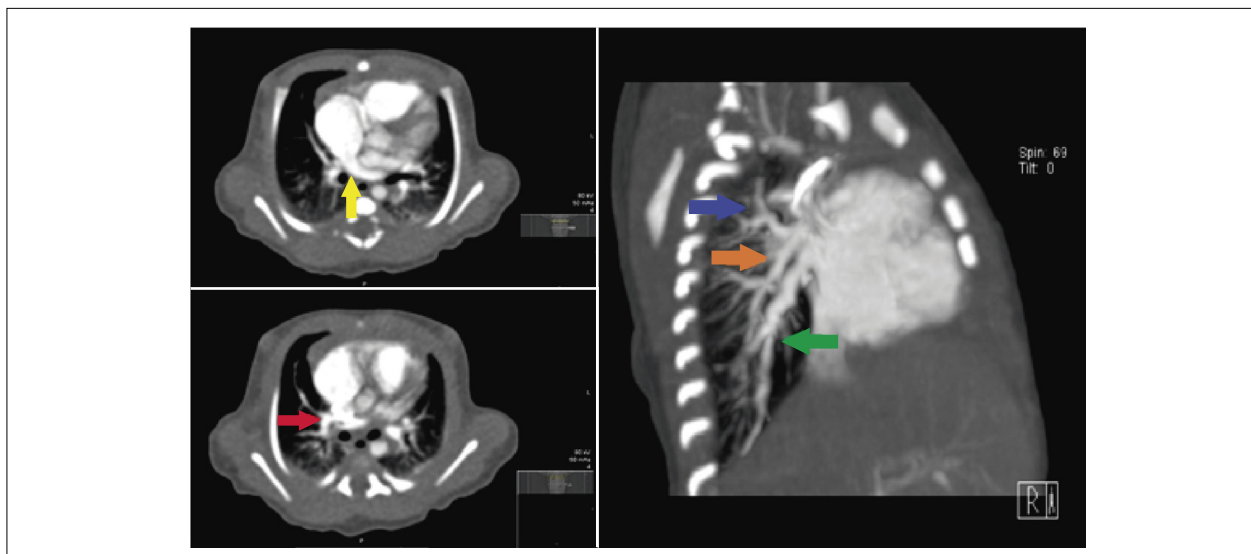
Axial view of the chest Computed Tomography Angiogram (left sided images) showing a common trunk coming from the left pulmonary veins and draining into the right atrium (yellow arrow) and the right inferior pulmonary vein merging into the aforementioned common trunk (red arrow). Right anterior longitudinal view of the chest Computed Tomography Angiogram (right image) revealing the right superior (blue arrow) and right middle (orange arrow) pulmonary veins flowing into the superior vena cava and the right inferior pulmonary vein merging into the common trunk, which in turn drains into the right atrium. The green arrow is highlighting the right inferior pulmonary vein.
